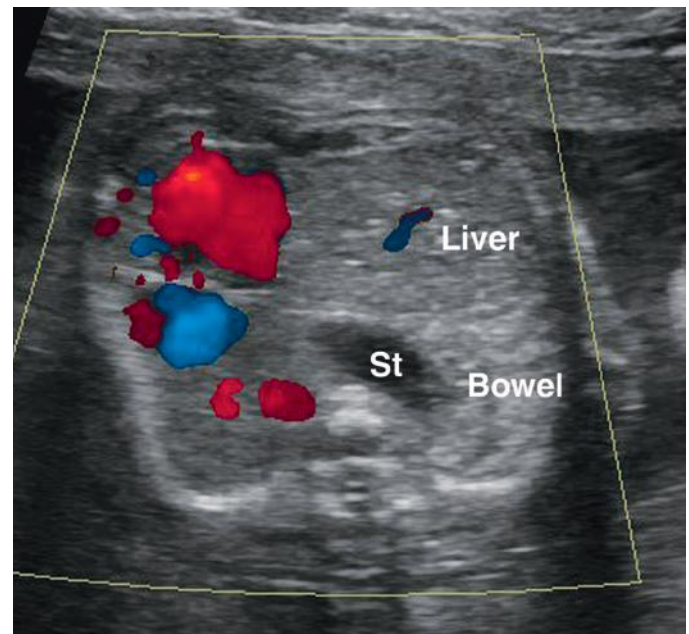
Two axial sonographic views through the chest in a fetus with a left congenital diaphragmatic hernia. Stomach (St), bowel, and portion of liver are herniated into the left hemithorax. Rightward shift of the heart (H) is also evident.
